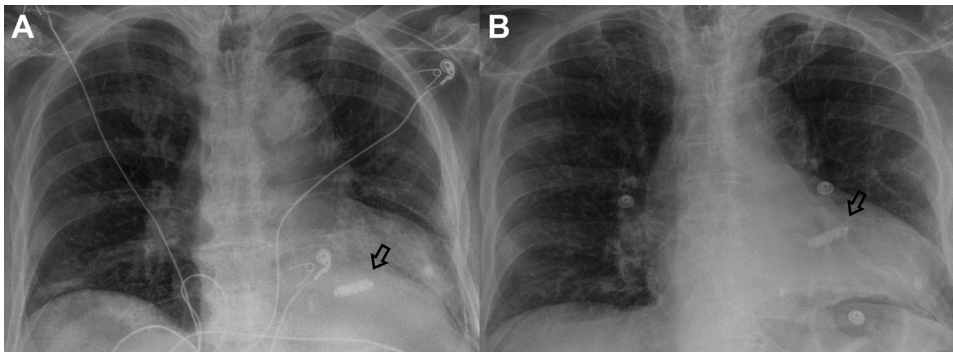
Chest radiographs demonstrating location of the Micra pacemaker (Medtronic Inc, Minneapolis, MN), both immediately (A) and 1 day (B) following implantation. The position of the Micra pacemaker remained unchanged on chest radiograph (arrow).
